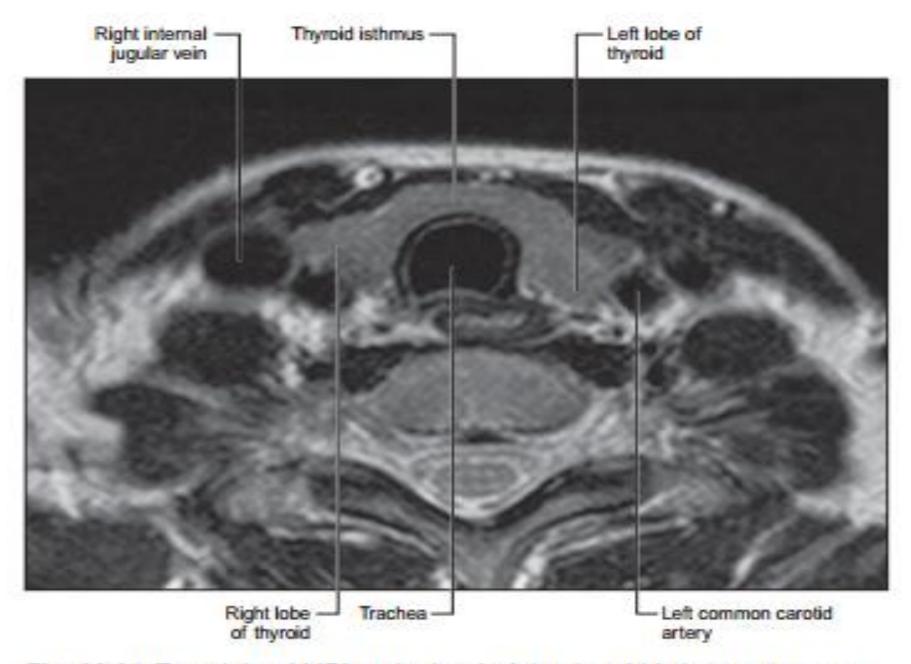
T2-weighted MRI at the level of the thyroid isthmus: compare 4/29/2020 With Fig. 28.20.
